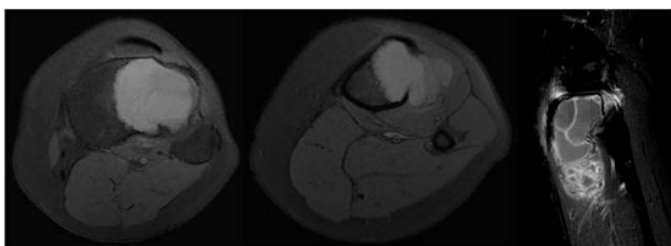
ABC, female, 29 years old, proximal tibia, type IC (MRI), fluid-fluid level $\geq 2/3$, solid content, soft tissue mass, no fracture. Score 4.
